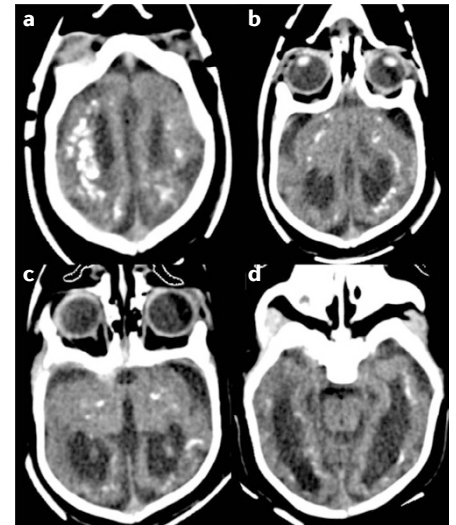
Intracranial calcifications. Axial head CT images of an infant with congenital microcephaly related to intrauterine Zika virus infection. a,b | Band-like and larger calcifications. c | Isolated and punctate calcifications. d | Band-like and larger calcifications. Calcifications are observed at the level of the corticomedullary junction (part a) and periventricularly within the frontal, parietal and temporal lobes (parts a–d), as well as within the basal ganglia (parts b,c). In addition, global cortical hypogyration, moderate ventriculomegaly, and abnormal hypodensity of the supratentorial white matter are noted. Images from the Medical Research Council-funded Digital Imaging Platform project, courtesy of Andrea Poretti (Johns Hopkins Children's Center, Baltimore, Maryland, USA).
